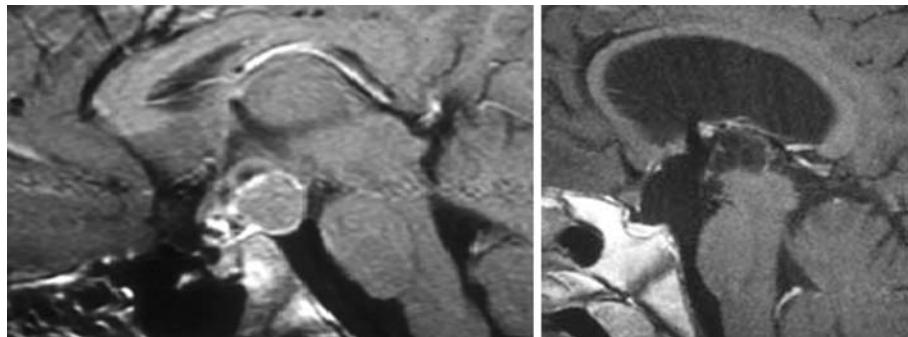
CP extending into the third ventricle through its floor. *Left*, preoperative MRI sagittal T1 view after injection. *Right*, postoperative MRI sagittal T1 view showing a large defect at the level of the floor
